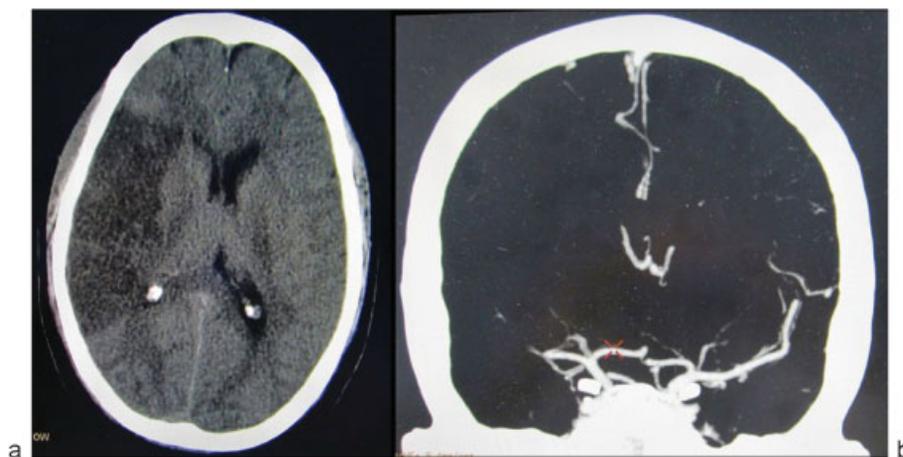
Case 2: (a) Computed tomography (CT) showing infarct in the middle cerebral artery territory. (b) CT angiogram showing complete occlusion of middle cerebral artery in M1 segment.
